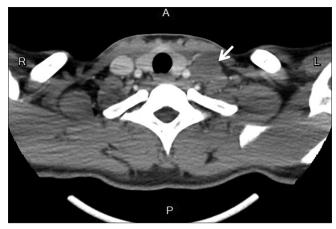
Neck contrast-enhanced computed tomography showed a mass lesion over the left neck (white arrow)
